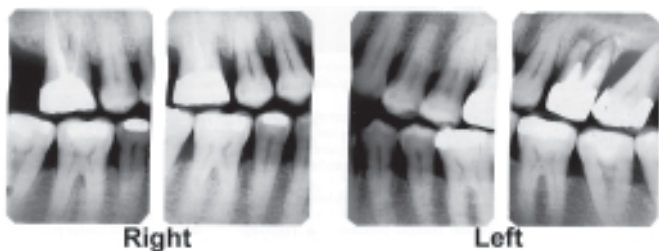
Showing example of typical RIGHT and LEFT vertical adult bitewing radiographs. Note that two films are used on each side to image both the premolars and molars
